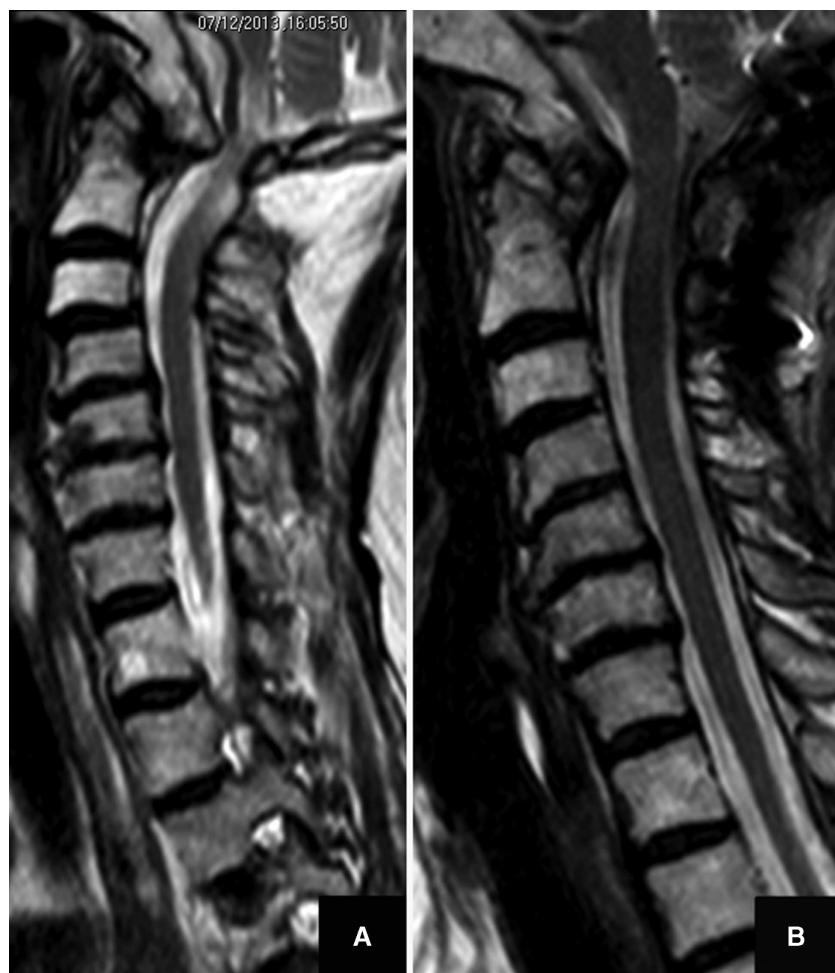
Preoperative (A) and 6 months follow-up (B) MRI demonstrating the posterior shift and relief from compression of the spinal cord.
